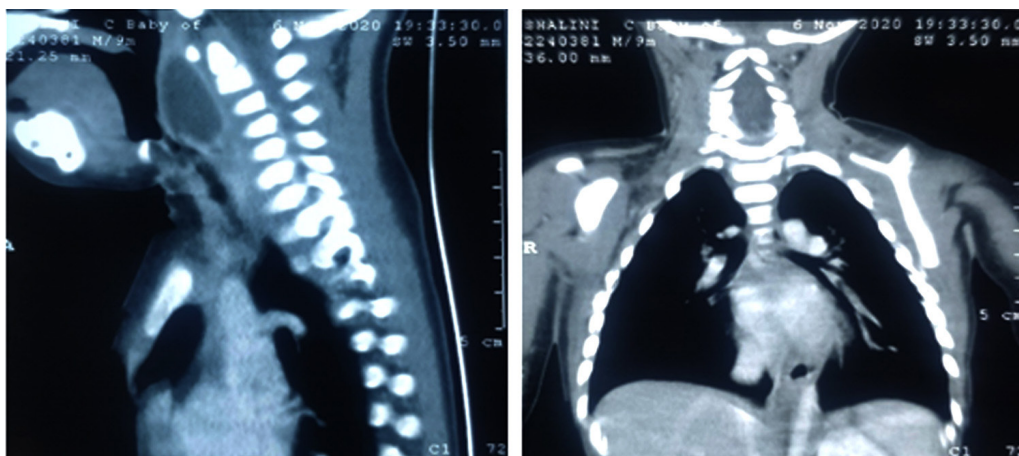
CT neck and thorax revealing the abscess in C1 to C4 levels:
